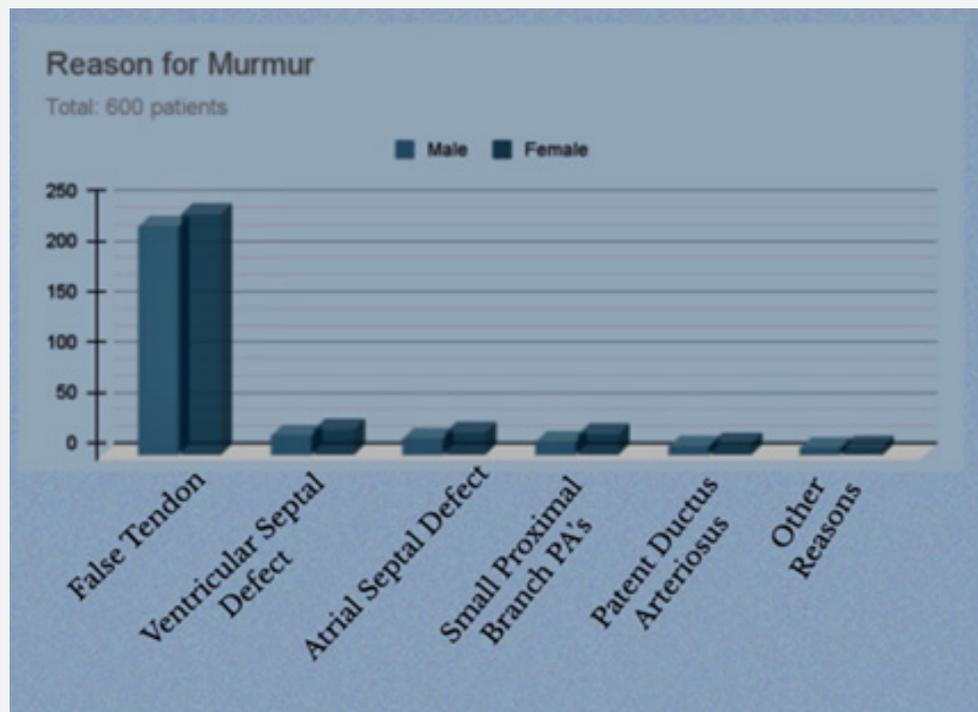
Distribution of echocardiographic findings among children referred for murmur evaluation.
